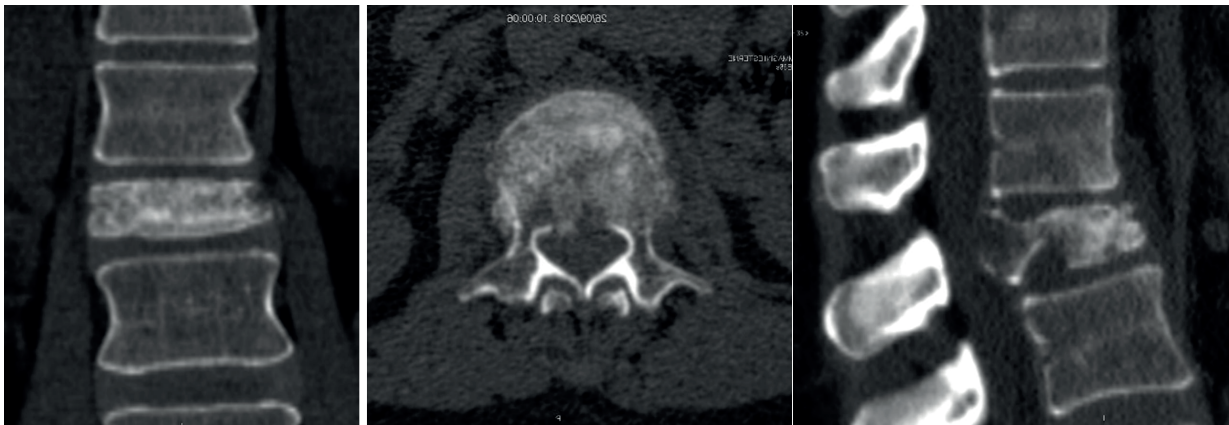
Pre-operative CT-Scan in coronal, axial and sagittal planes showing adenocarcinoma metastasis of L2 with collapse of vertebral body. This patient was treated by thermal-ablation and stabilization using CARBON/PEEK materials.
